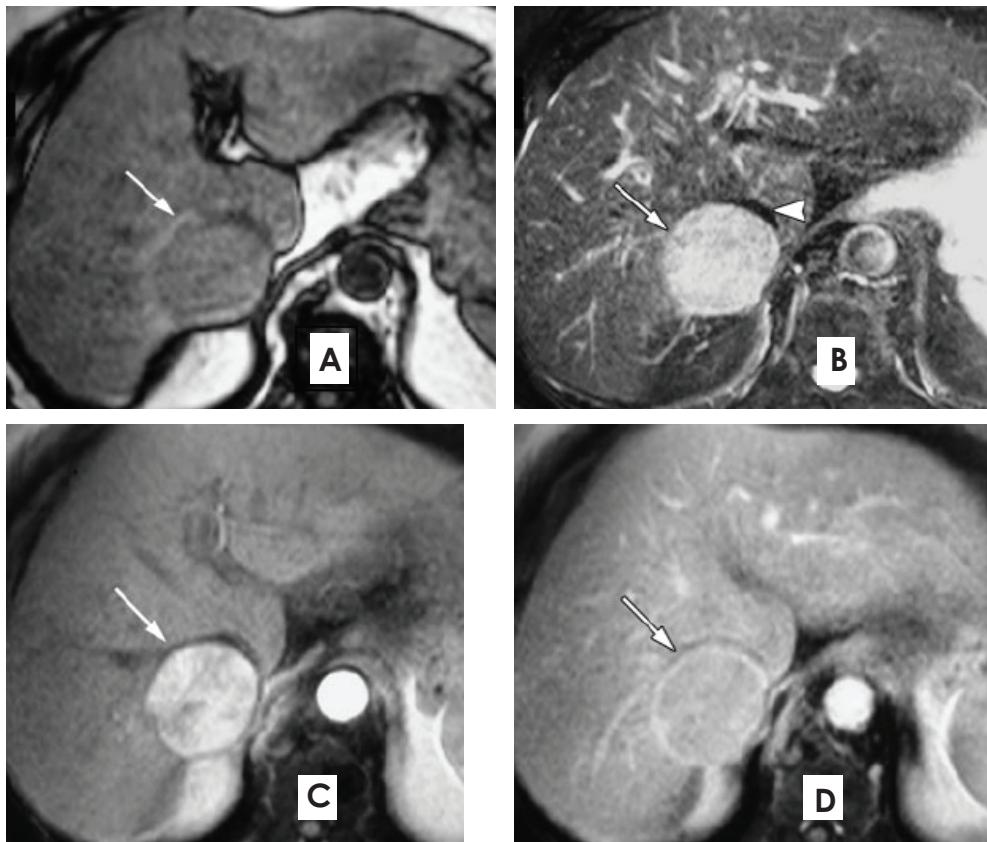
HCC in NAFLD in a 71-year-old obese man with diabetes. MRI shows fatty liver (A) containing a well-defined, encapsulated mass. This mass shows high SI at T2 (B), rapid enhancement (C) and rapid washout (D), consistent with HCC.
